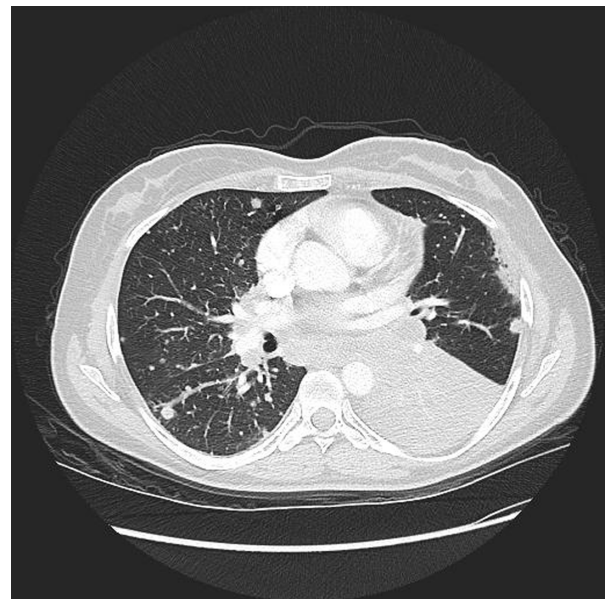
Axial CT image with lung window shows multiple round lesions both lungs in keeping with metastases.
